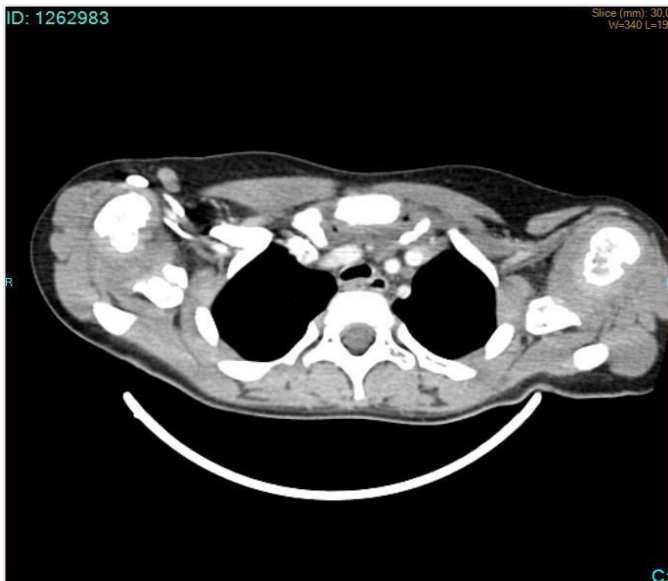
Preoperative thorax CT angiography: Hypertrophic osseous lesion on the head of right clavicle compressing on vascular structures and the trachea
